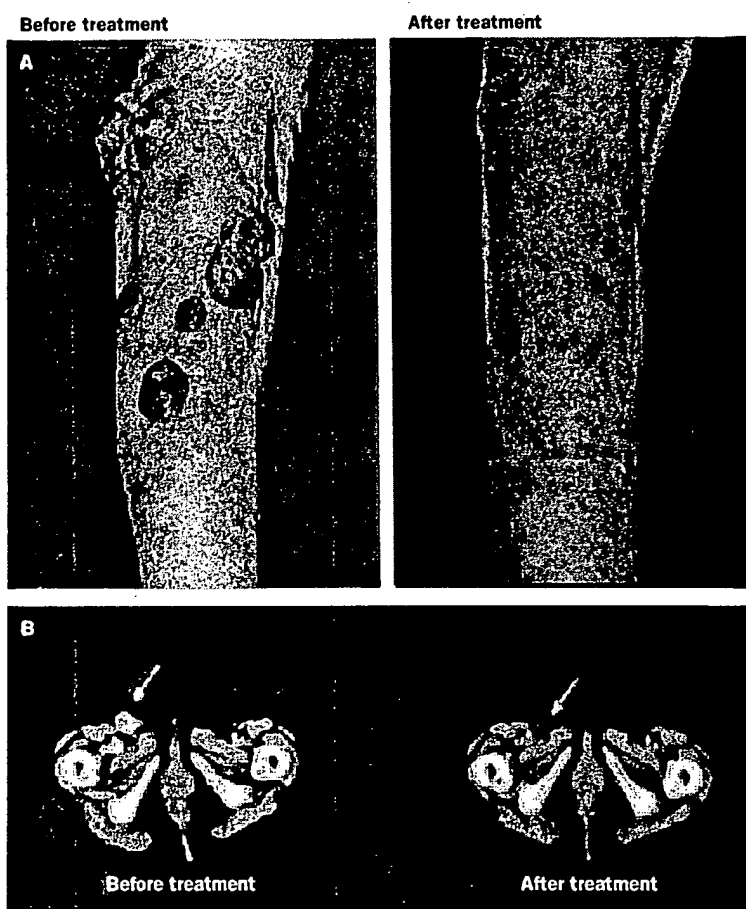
An example of a complete remission of advanced malignant melanoma after chemosensitisation by BCL-2 antisense (Genasense) treatment. Lower right leg (a) and a computed tomography of the pelvis (b) before and after treatment are shown (reference 31).
